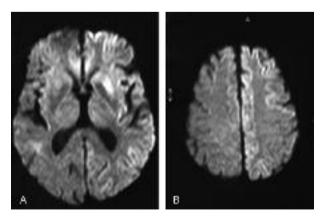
Axial DWI MRI (A-B) shows hyperintense signals in the left caudate nucleus and putamen as well as in the left cerebral cortex.
